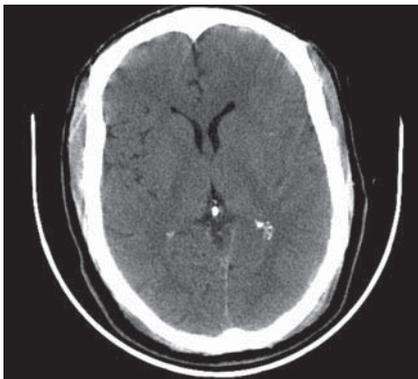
Initial CT scan of a young male patient after a motor vehicle accident. Early findings include sulcal effacement on the left but no obvious haemorrhage.
